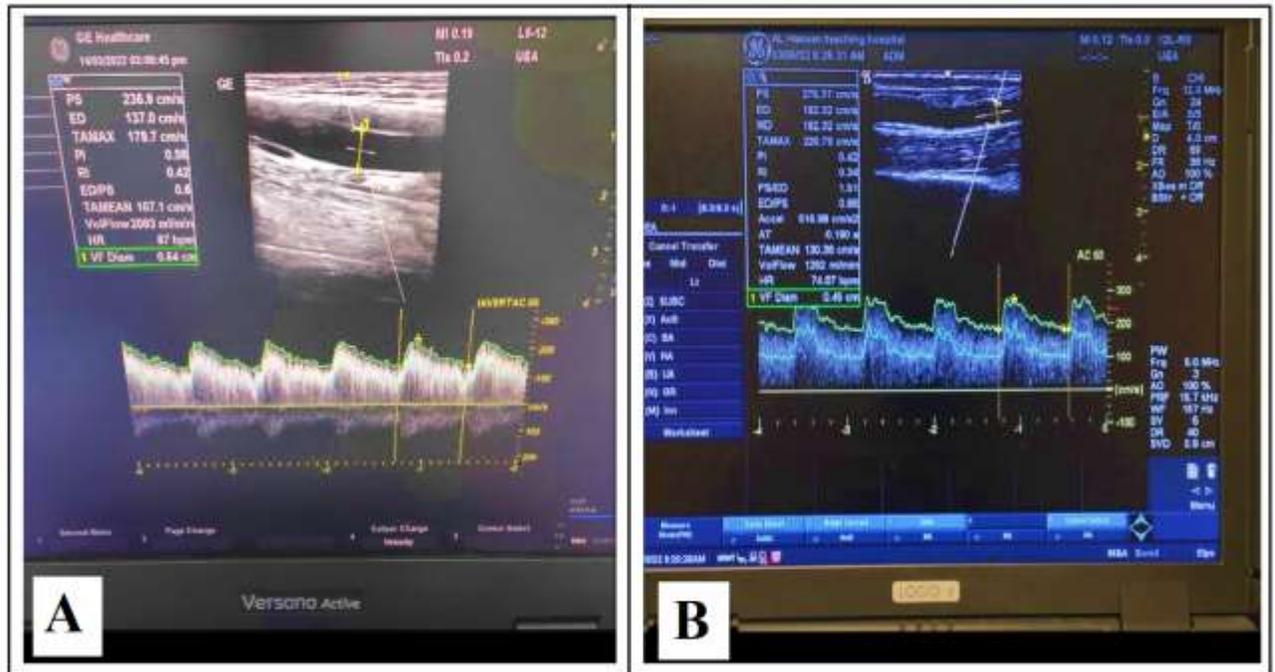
Ultra-sonographic flow velocity measurements of native arteriovenous fistula
